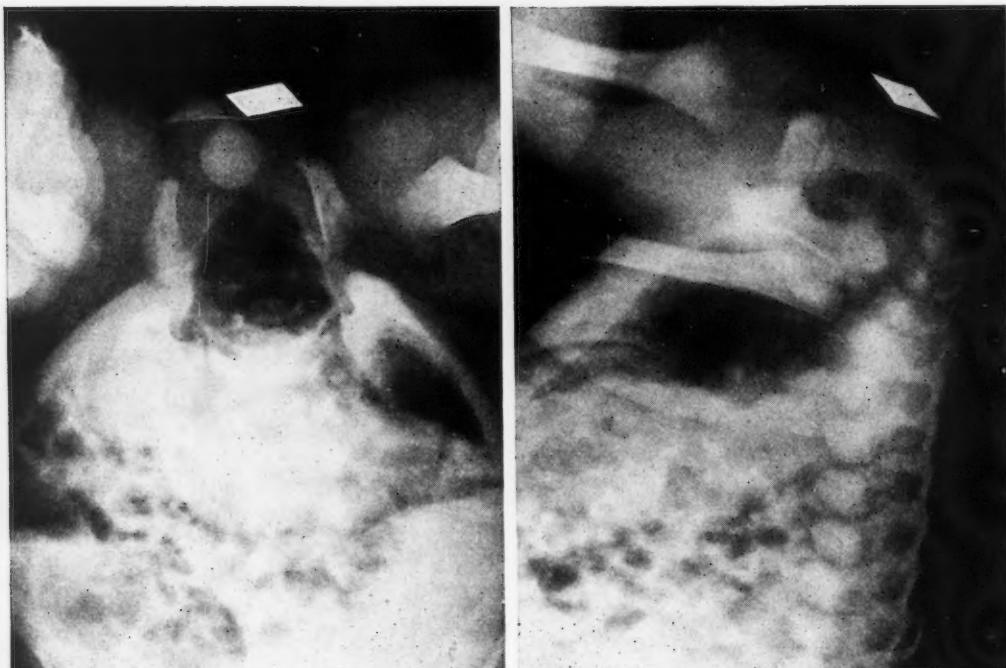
Roentgen demonstration of blind end of bowel filled with gas. Case 6.
